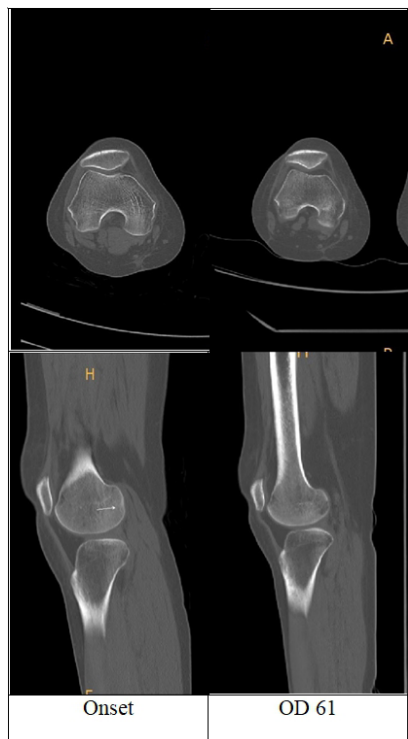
Computed tomography of the right lateral femoral condyle. OD, onset day: days after the onset.
